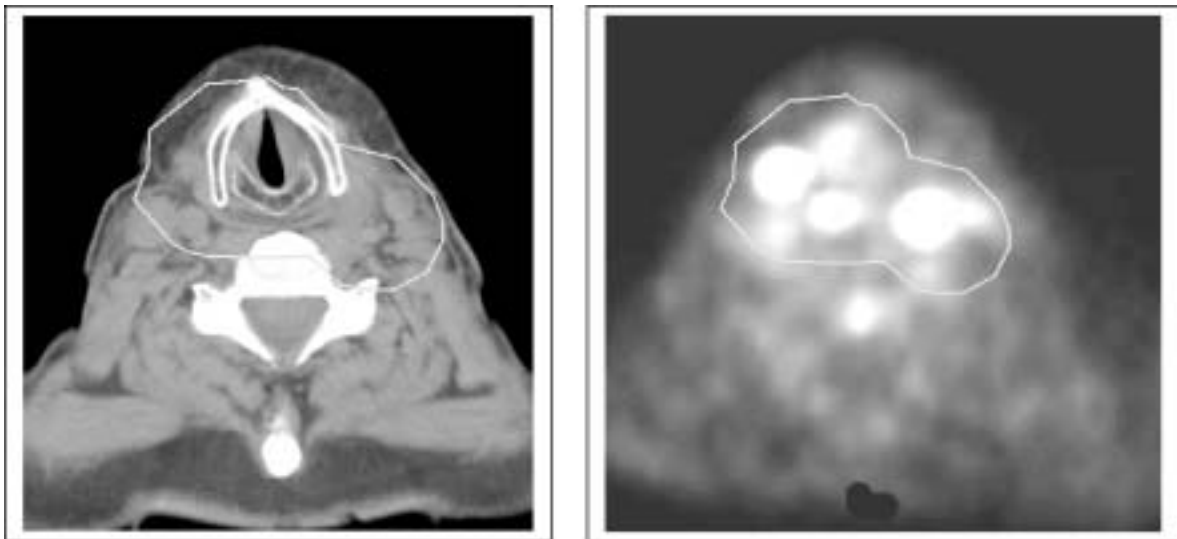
FDG-PET and CT images for a patient with thyroid carcinoma. The images were obtained with the patient in the treatment position, registered, and then used for localization of the target volume.
